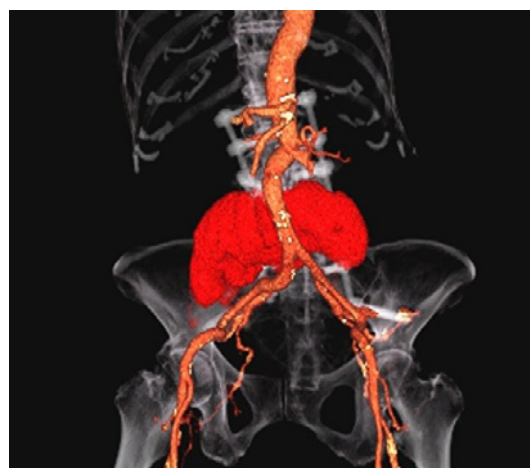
Sixty-one days after the injury, fifty days after the spinal surgery, contrast-enhanced CT, 3D angiography, frontal view.
